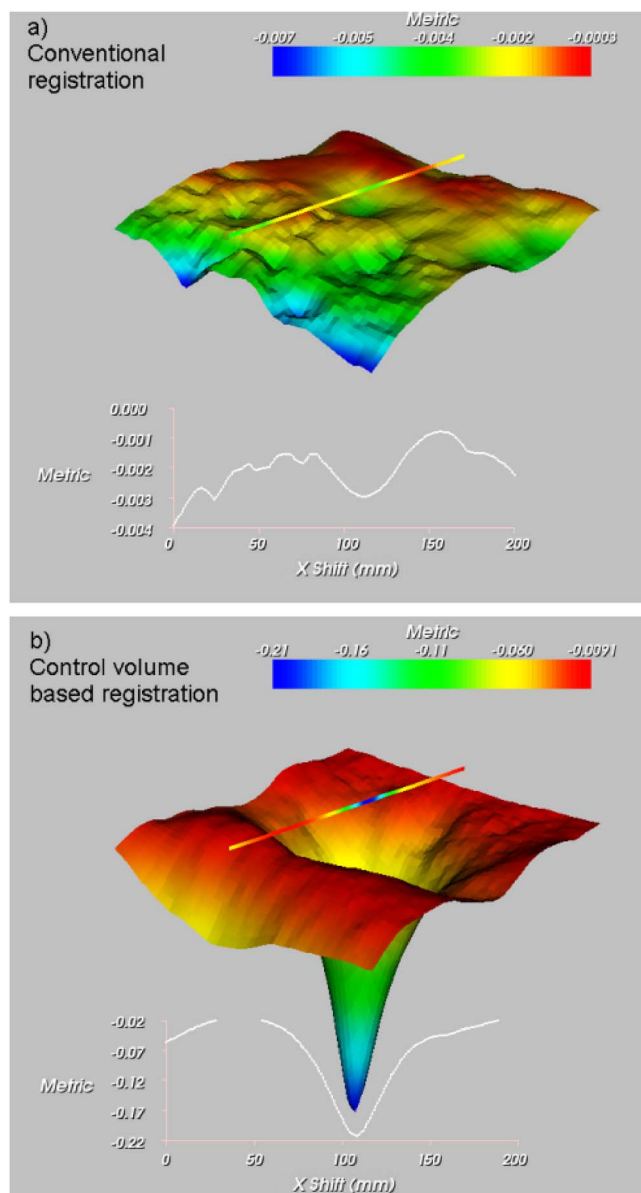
Metric space of FLT-PET and CT registration when the whole image set is used (a) and when three control volumes on the bony structure are used (b).
